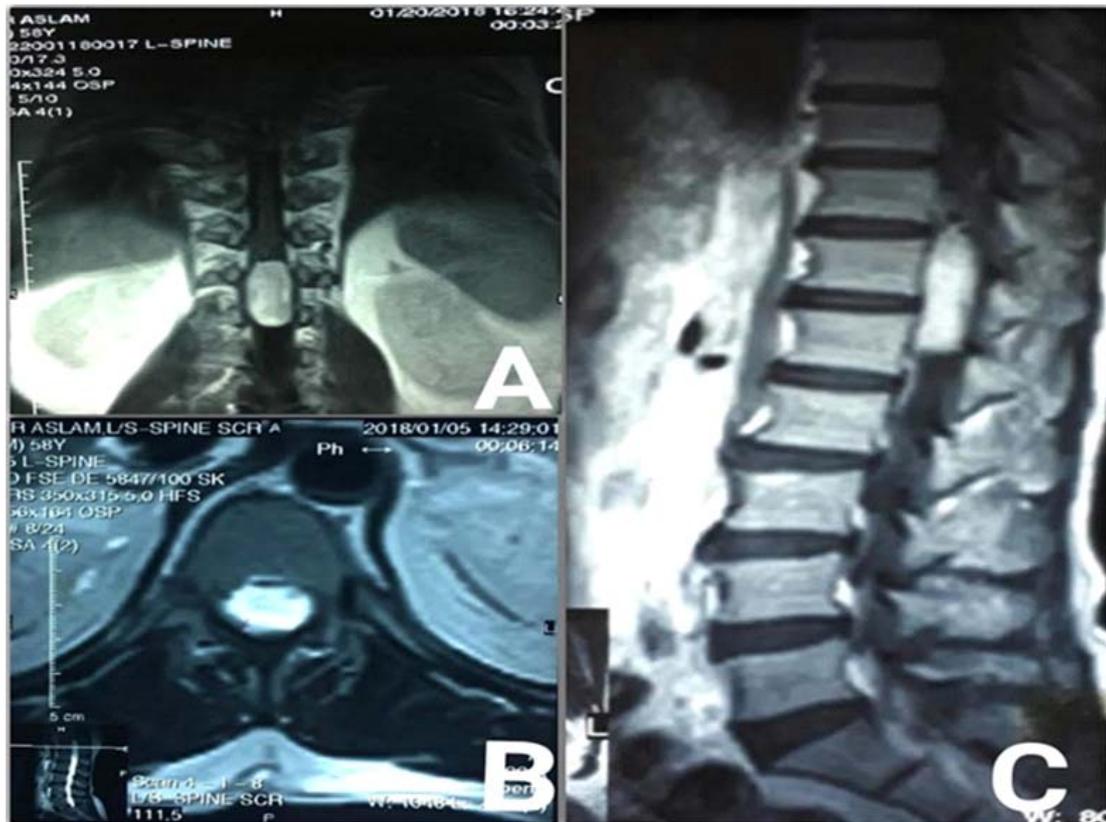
MRI lumbosacral showing a hyperintense area on T2 weighted images extending from T12-L1 as shown in Coronal (A) and Sagittal planes (C), and Transverse (B) plane
